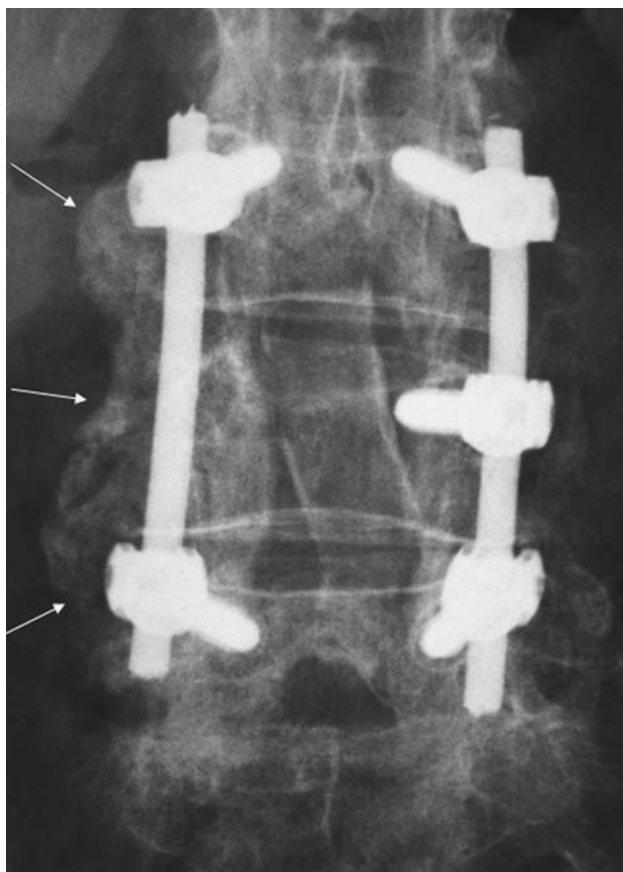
A follow-up AP radiograph to that shown in Fig. 1 taken 1 year post-surgery demonstrating “fusion” according to the Christensen et al. criteria for all intended fusion levels. The fusion mass is particularly well visible on the patient’s right side (see arrows), demonstrating new bone formation and mineralization
